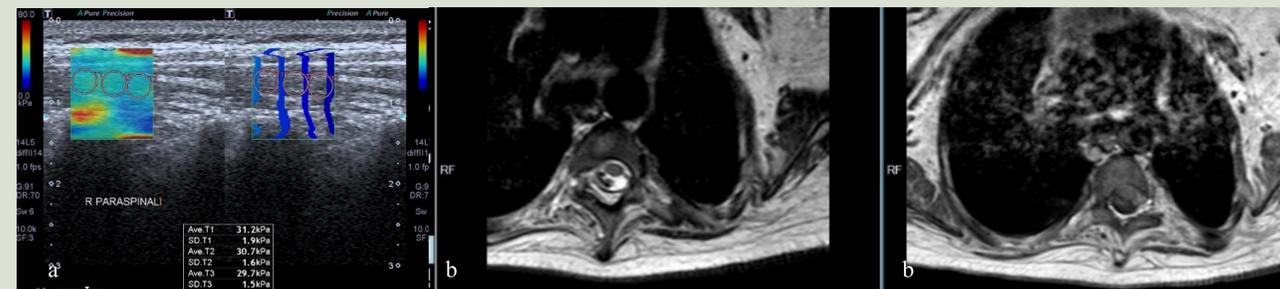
Elastography and MRI images of a patient with SMA type 2
